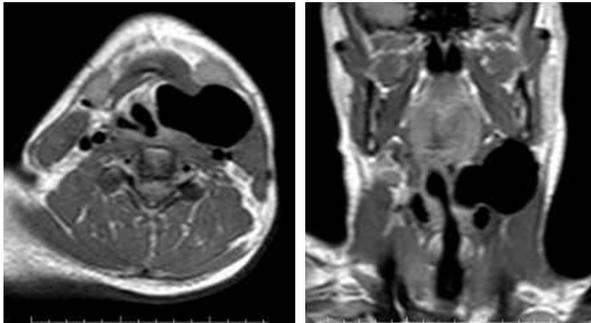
In axial and coronal contrasted sections of obtained in magnetic resonance imaging revealed a 4x3 cm lesion of air density extending from the thyrohyoid membrane to the band ventricle and ventricular region of the endolarynx with peduncles at the hyoid bone level on the left side of the neck.
